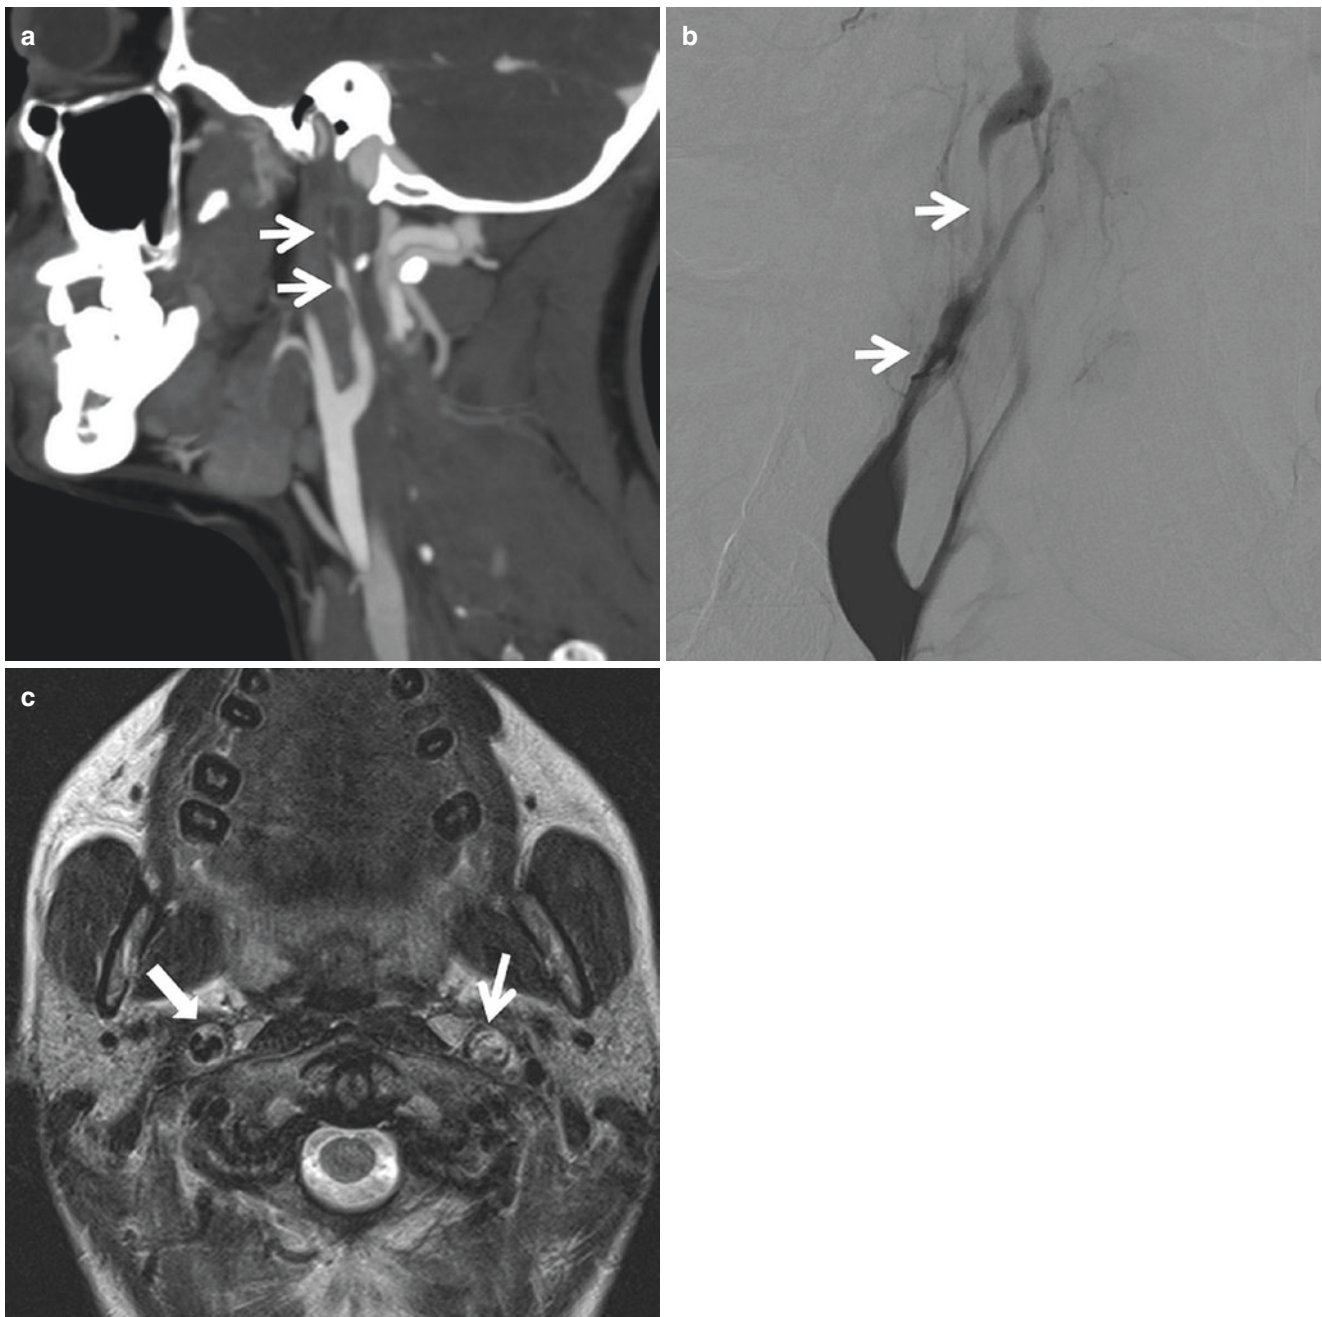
Grade II ICA injury with intramural hematoma. Axial CTA (a) shows near-occlusive irregular luminal stenosis involves a long segment of left cervical ICA due to compression of an intramural hematoma (arrow), consistent with grade II injury. This is confirmed by
